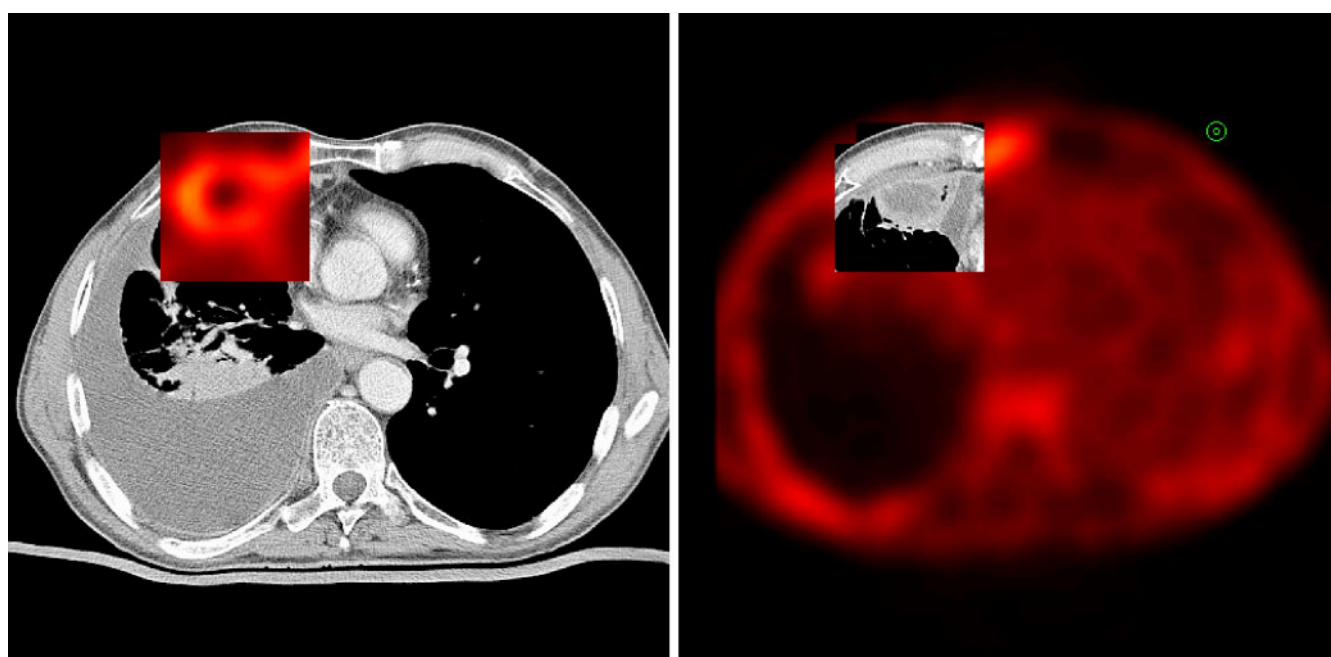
^{99m}Tc -maraciclalide study showing SPECT/CT registration. Primary cancer seen in right lung (note annular uptake and necrotic center). Right lung also shows pulmonary effusion.
